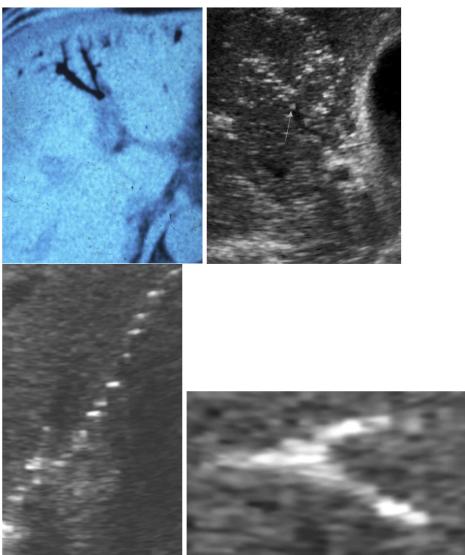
a-d No aerobilia (false diagnosis by CT), but gas filling ("air") in the portal system (left and middle third of the picture); aerobilia is as a rule less diffuse and characterized by a more vivacious pulsatile motion (c and d, with section magnification in c); SCS right
